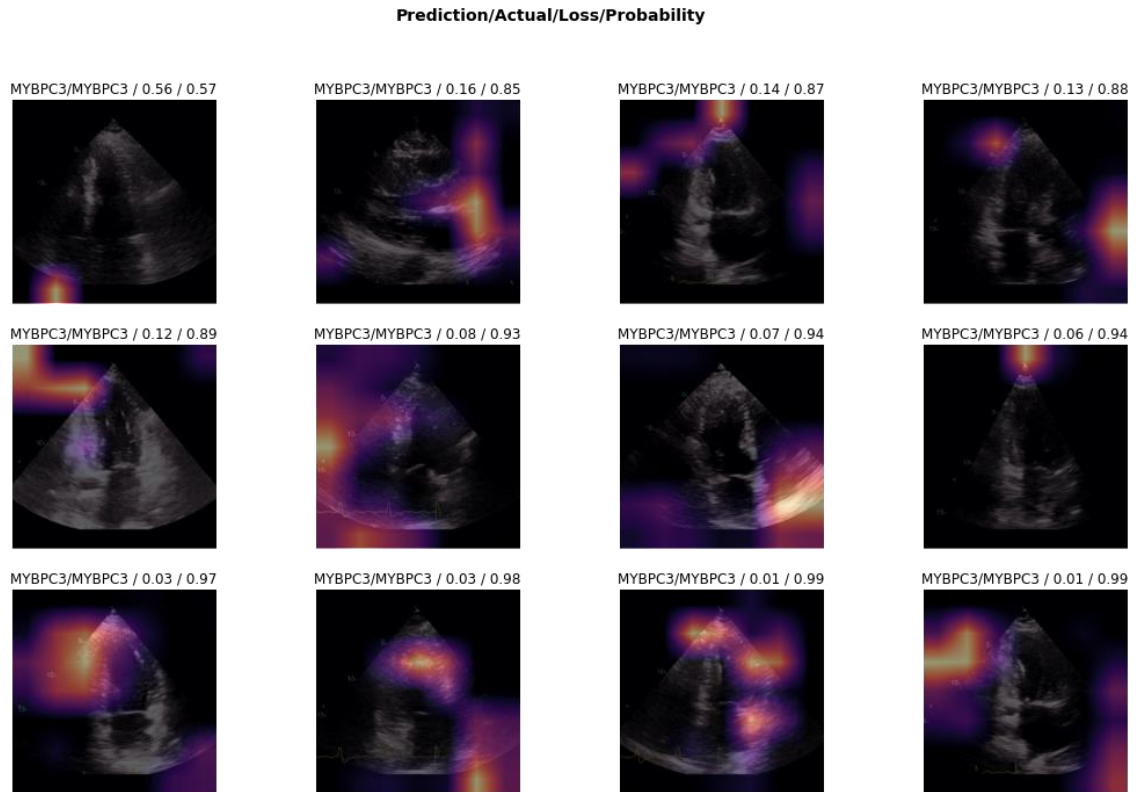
Discriminative areas for classification of a given image (*MYBPC3* vs. ND), apical 2-chamber view during ventricular systole
